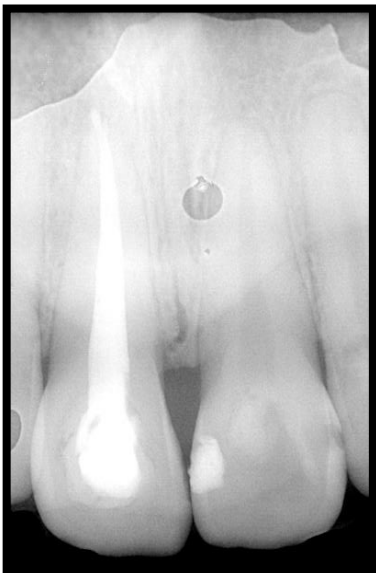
Pre-operative radiograph showing gutta percha going beyond the apex
